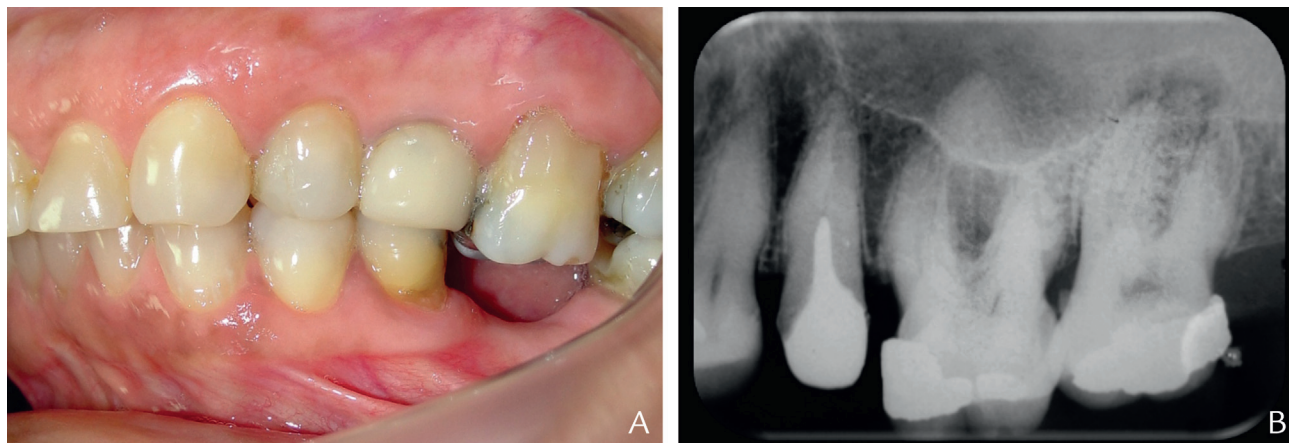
Pretreatment. A, Lateral view. B, Periapical radiograph.
